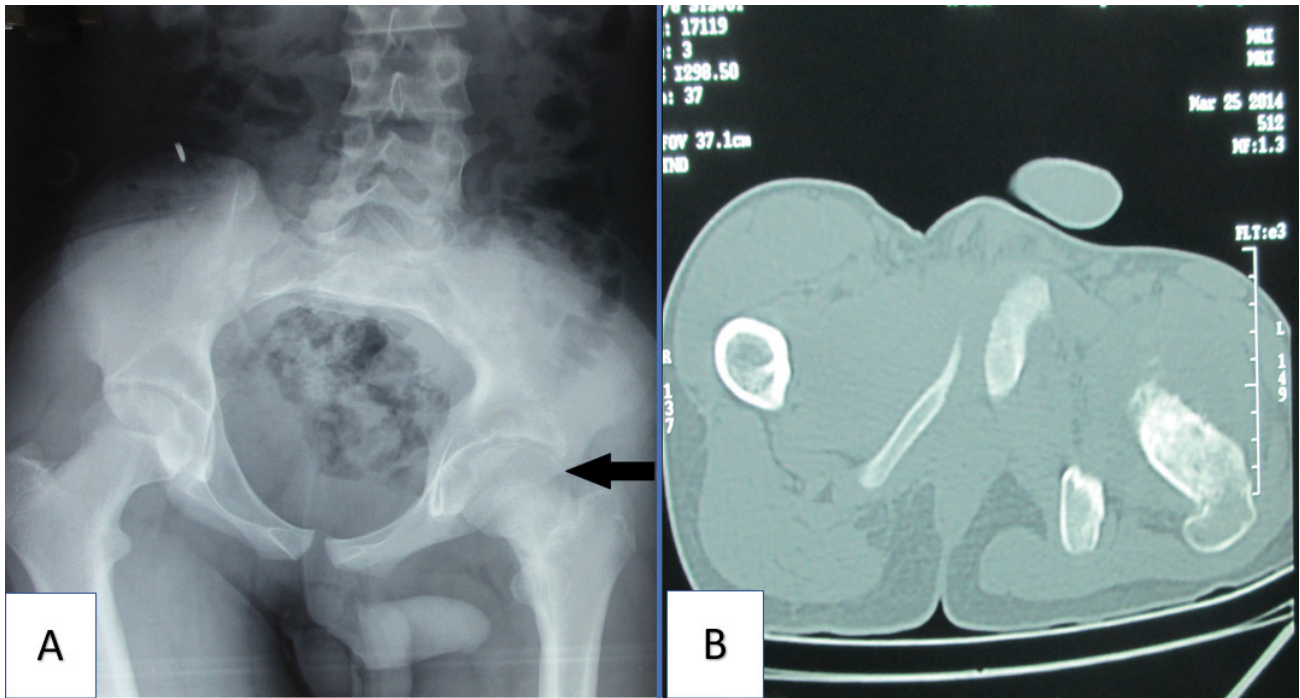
Radiograph of hip joint shows mixed lytic and sclerotic lesion involving the femoral head and neck.
